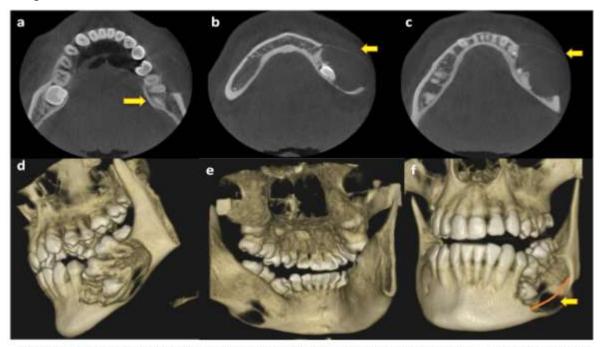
(a,b,c,d,e,f) :Axial sectioning and three dimension of CBCT revealed a well defined hypodense area in the posterior left mandibular region in relation to 35, 36 and 37 with a well delineated corticated border. The axial section revealed an expansion of the buccal bone (b) and thinning of an adjacent buccal cortical plate leaving a thin "eggshell" of bone (C) The trabecular pattern of the mandible surrounding the lesion was altered (a) Three dimension with nerve traced model showed that the inferior alveolar canal and inferior alveolar nerve displaced inferiorly towards the lower border of mandible and approximated within the lesion (f).
